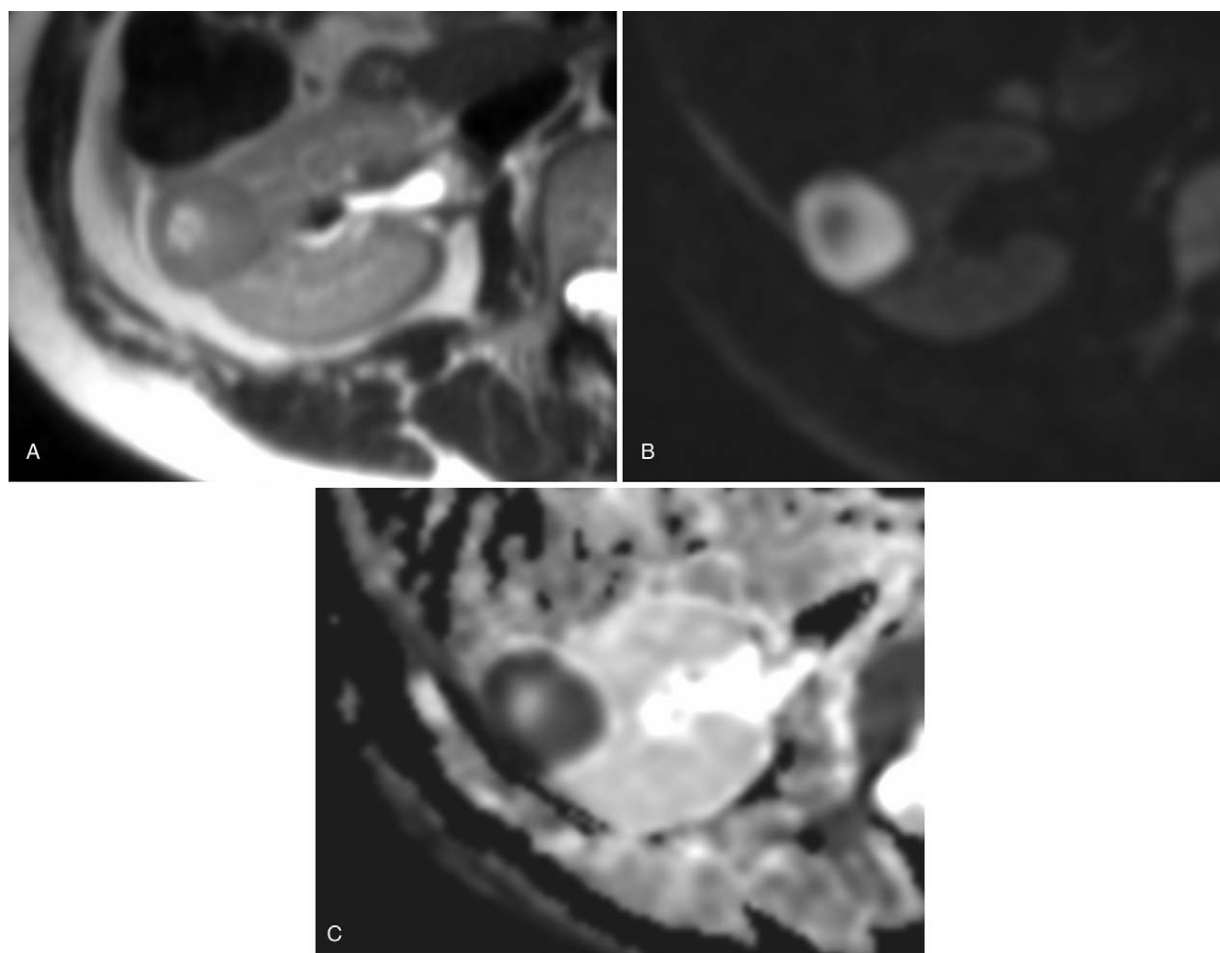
Magnetic resonance imaging (MRI) of the right kidney. (A) T2 weighted imaging shows a well-demarcated, hypointense nodule with cystic area at mid-pole of the right kidney. (B) Diffusion weighted image with b -values of 1000 s/mm^2 and (C) apparent diffusion coefficient mapping confirmed fluid restriction in the nodule, implying highly cellular nature of the nodule.
